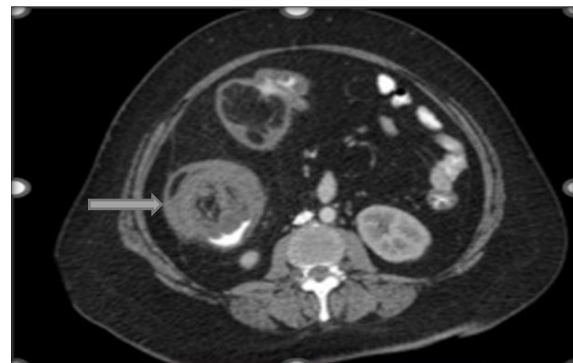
Axial contrast enhanced CT image of abdomen showing bowel within bowel sign (Target sign) in the right lumbar region (grey arrow), suggesting intussusception with presence of orally administered contrast in the intussusciption's lumen
